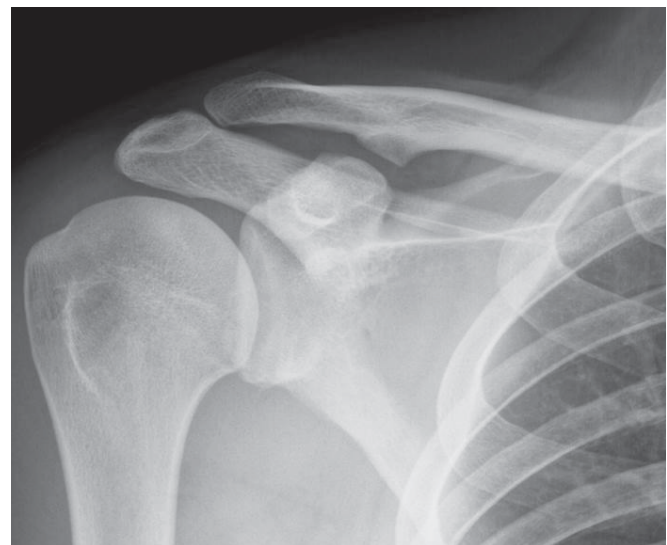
A radiograph of the coracoclavicular joint.
